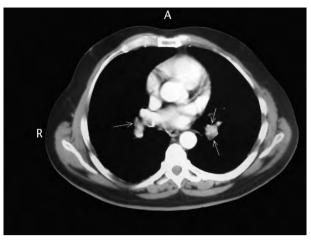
Chest CT scan. Repletion defects in peripheral regions of both main pulmonary arteries and in the descending branch of the left pulmonary artery related to a pulmonary embolism. Anticoagulant treatment was begun with a favourable outcome.
